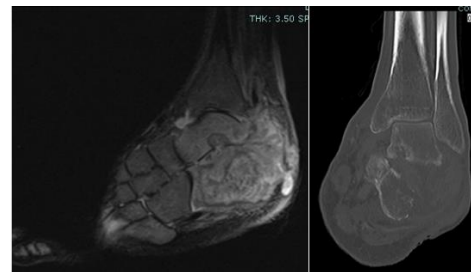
MRI of the left ankle
